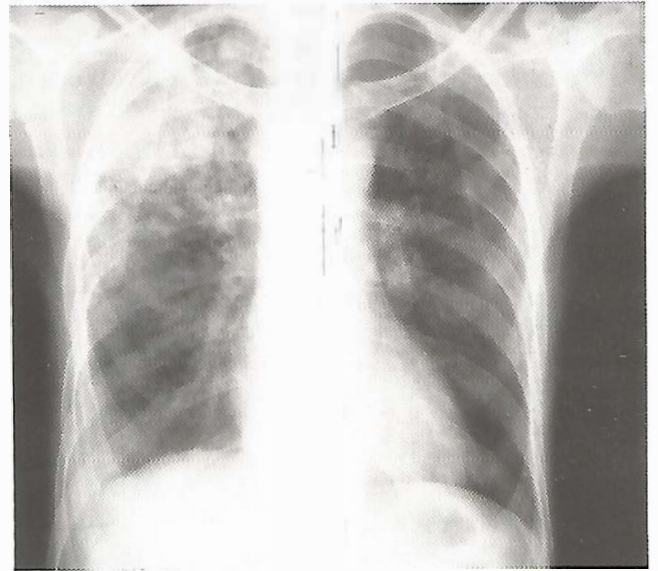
Chest X-ray showed infiltrate in right lung.
